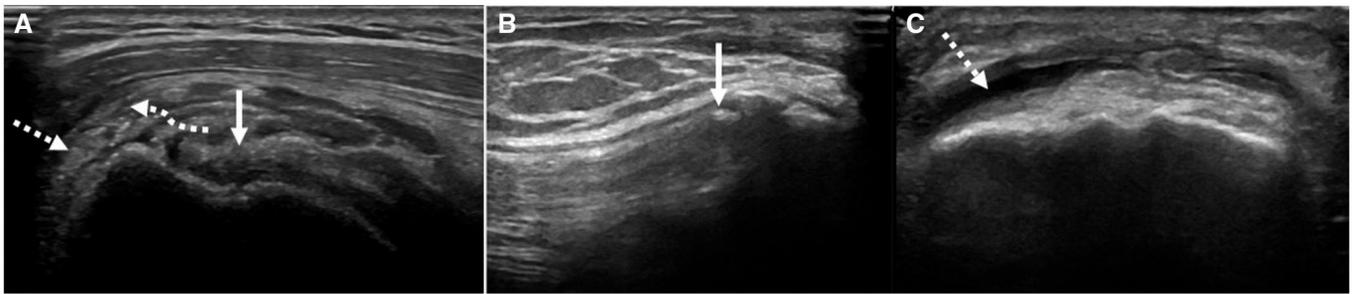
Calcific tendinopathy with bursal migration: (A) ultrasound image showing type 3 calcification in the supraspinatus tendon (white arrow) with migration of calcium (curved dashed arrow) into the subdeltoid bursa (dashed arrow), (B) grey scale ultrasound image of quadriceps tendon showing calcific tendinopathy (white arrow) with reactive bursal thickening with bursal effusion (dashed arrow) suggesting prepatellar bursitis (C).
